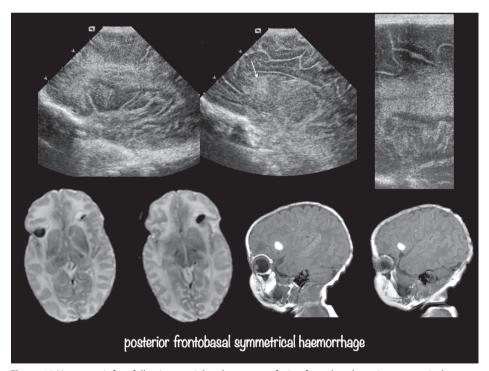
Near term infant following partial exchange transfusion for polycythaemia: symmetrical posterior basofrontal haemorrhage is surrounded by extensive hyperechoic areas with high white matter signal on T2 MRI; arrow points to hyperechoic caudate area. On US the lesions appeared less circumscript, suggesting a role for perilesional congestion in adjacent white matter. The absence of cavitation in the third week after birth suggested the tissue was not entirely infarcted.
